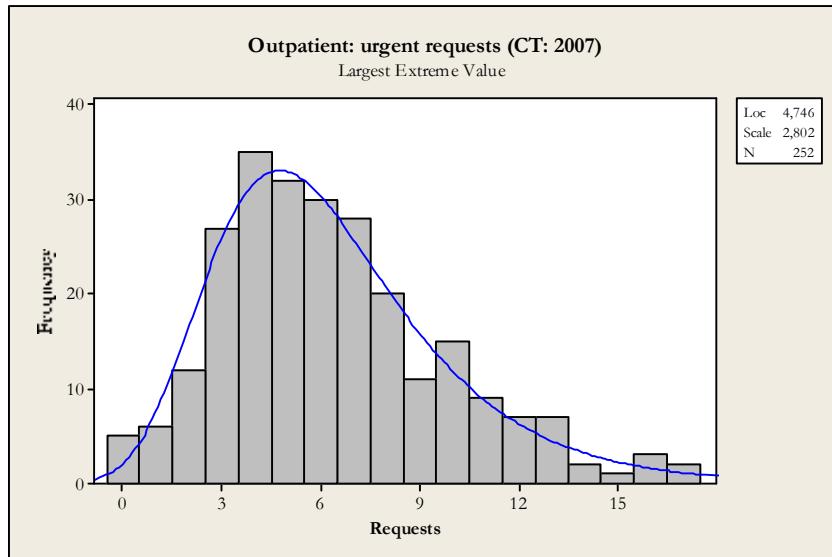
Fitted distribution for urgent outpatient CT requests (RIS: 2007). Distribution: max. extreme (Location: 4,75; Scale: 2,80).
